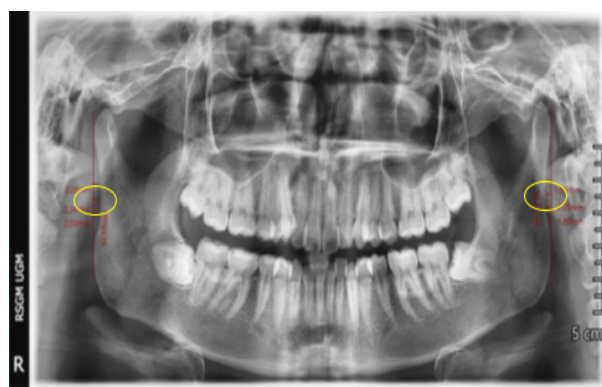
RND measurement on digital panoramic radiograph
